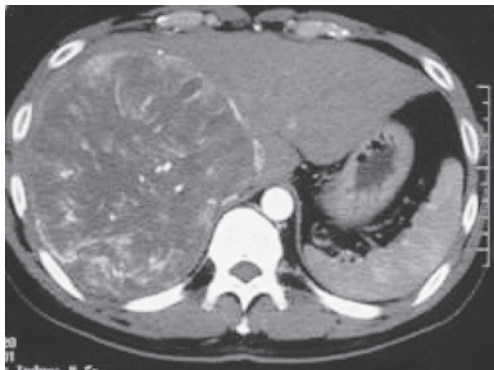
An abdominal computed tomographic scan, showing a large HCC that had invaded the right side of the diaphragm.
